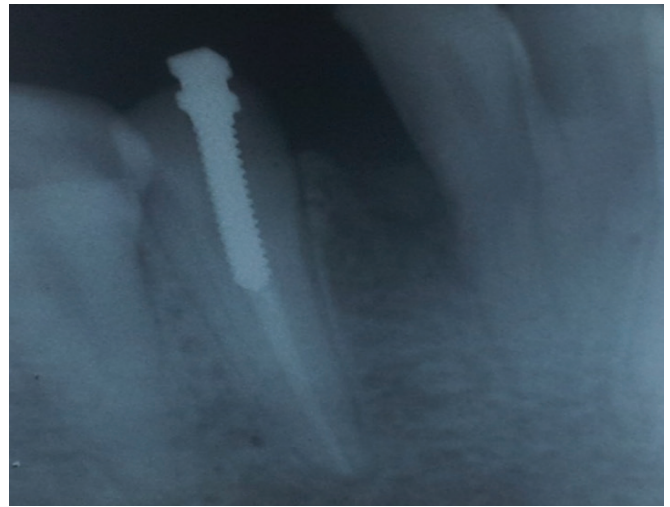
Radiograph of metal post-placement.
